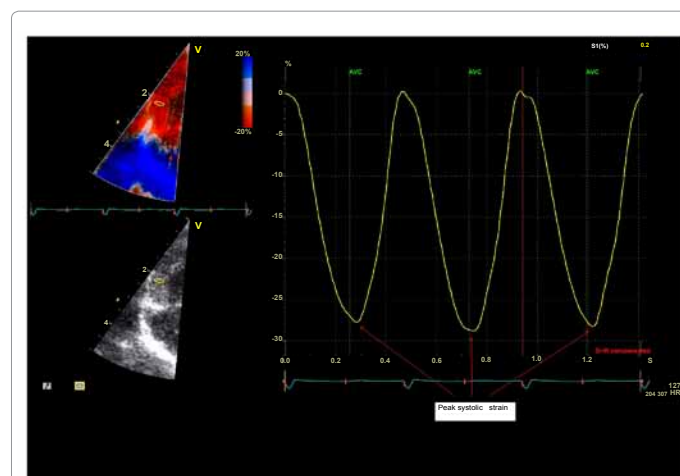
Analysis of strain by tissue Doppler from the mid segment of the right free wall obtained from the apical 4-chamber view in a healthy term neonate. Upper left Figure: Strain by tissue Doppler image. Lower left Figure: Grey-scale image. Right Figure: Strain curve for three consecutive heart beats. Red arrows mark the peak systolic strain values.
